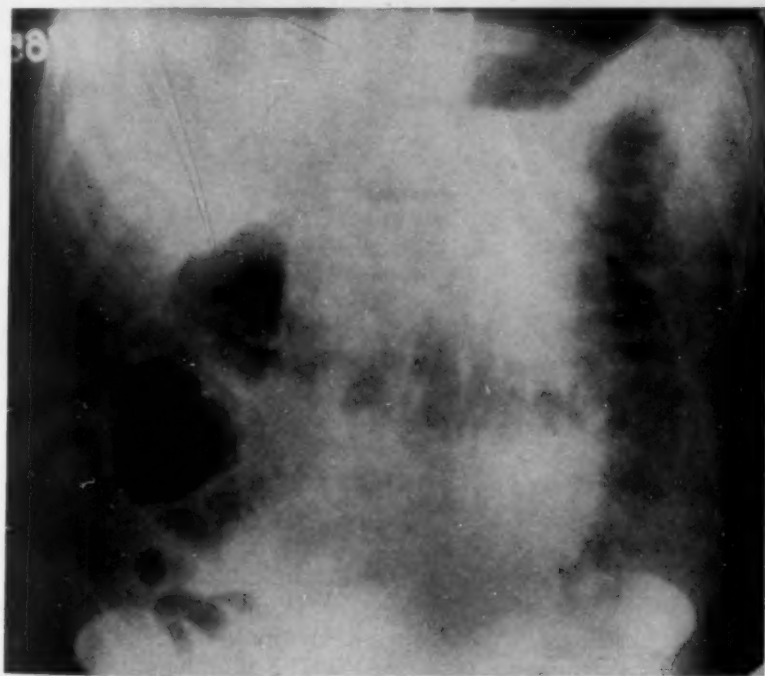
PA view. The liver-spleen visualization is of diagnostic value in cases of obesity, in whom palpation may be difficult or impossible. Note the well delineated liver edge and spleen outline in a markedly obese individual. The marked thickness of the fatty layers of the abdominal wall is evident in the radiograph. Liver and spleen are of normal size.
